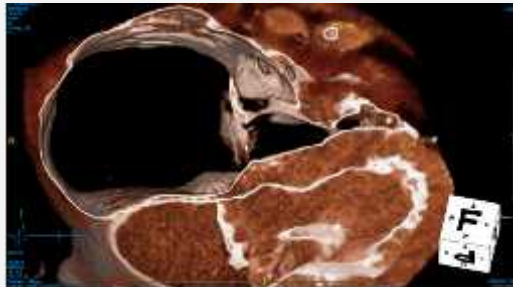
RV morphology by 3D reconstruction of Cardiac CT.
